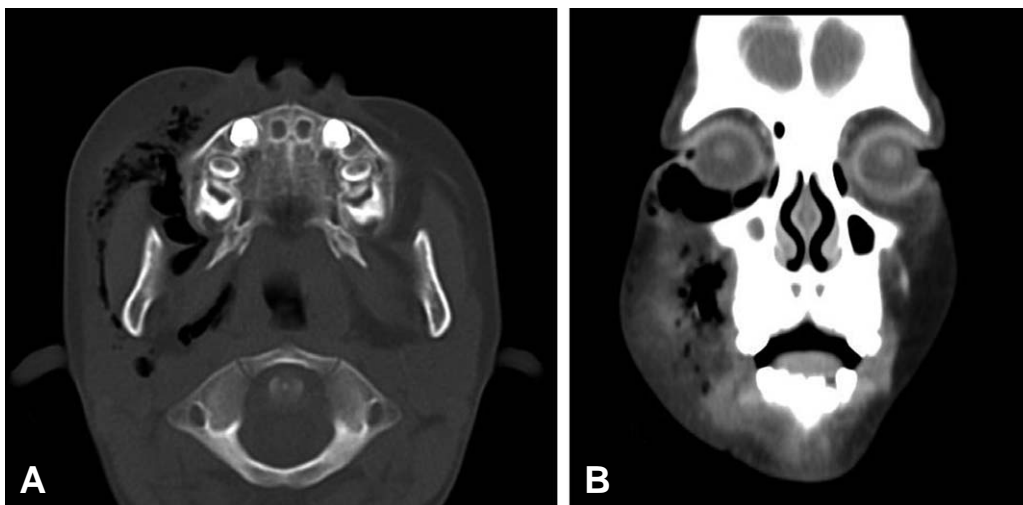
CT showing multifocal air density and resulting diffuse soft tissue swelling of the intratemporal fossa, premandibular, premaxillary, buccal, intraorbital and preorbital area (A, B).
